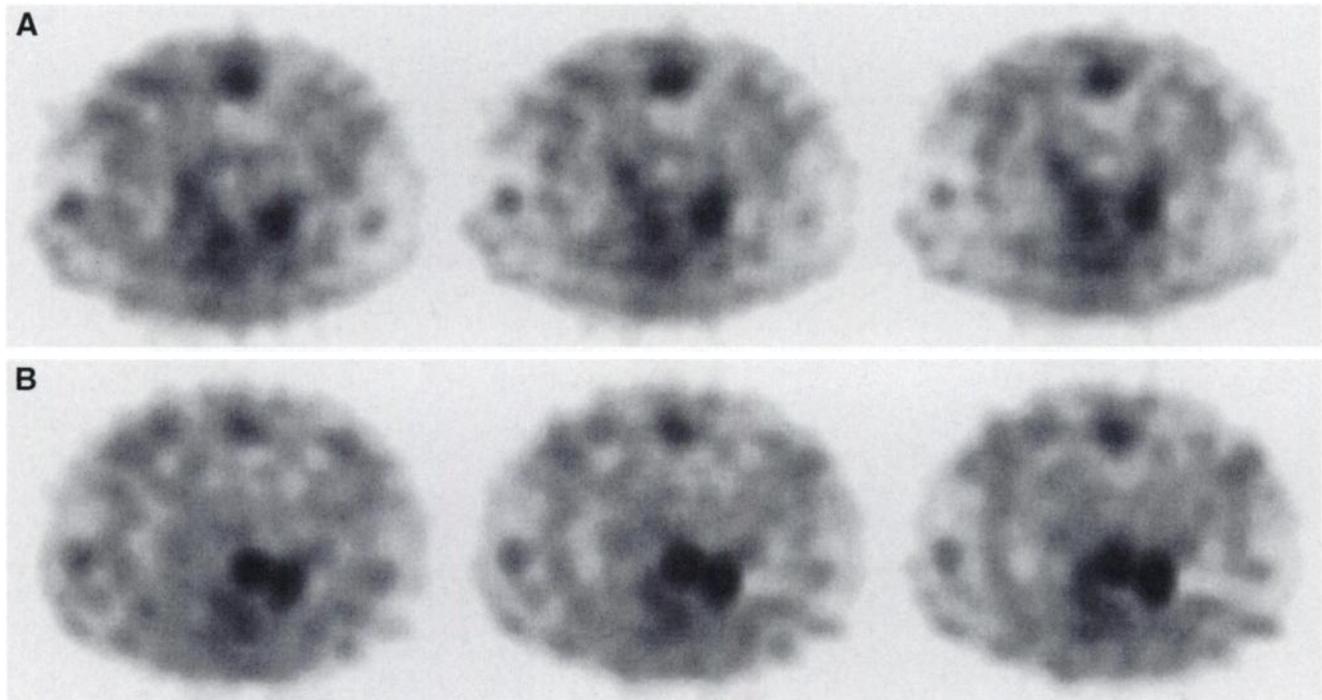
Three consecutive slices of axial SPECT studies in patient with transformed follicular lymphoma obtained at end of 6 cycles of CHOP (A) and 6 mo later (B). Note asymmetric HU with intense uptake in left hilum compared with right at end of chemotherapy (A). After 6 mo, focal uptake in left hilum has increased and new contiguous focus of abnormal uptake is seen (B).
